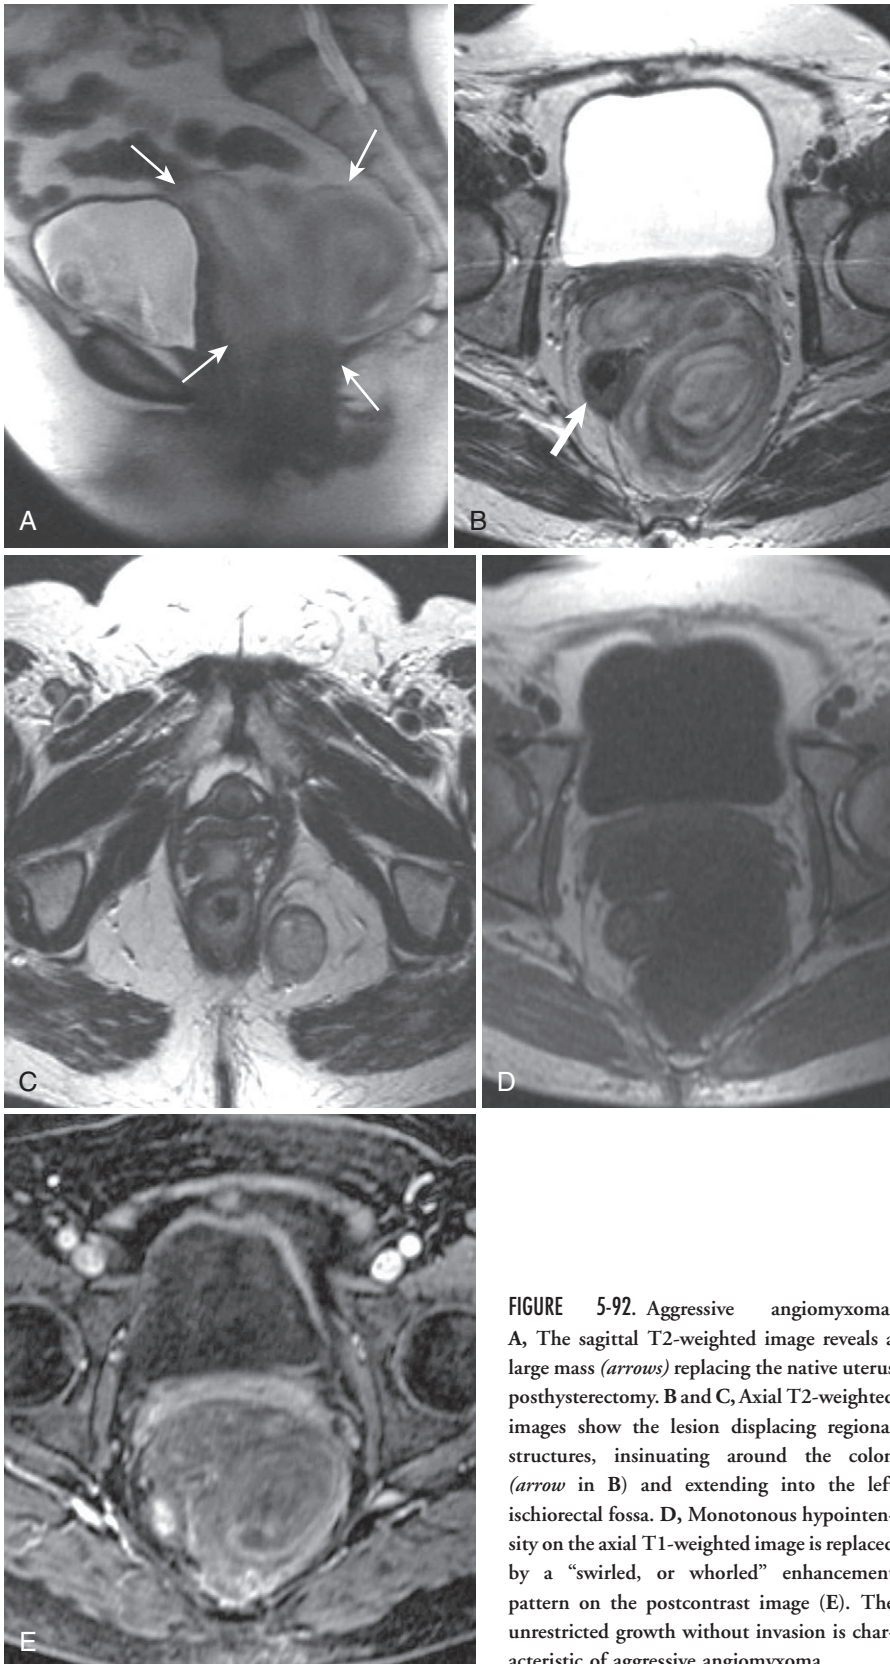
Aggressive angiomyxoma. A, The sagittal T2-weighted image reveals a large mass (*arrows*) replacing the native uterus posthysterectomy. B and C, Axial T2-weighted images show the lesion displacing regional structures, insinuating around the colon (*arrow* in B) and extending into the left ischio-rectal fossa. D, Monotonous hypointensity on the axial T1-weighted image is replaced by a “swirled, or whorled” enhancement pattern on the postcontrast image (E). The unrestricted growth without invasion is characteristic of aggressive angiomyxoma.
